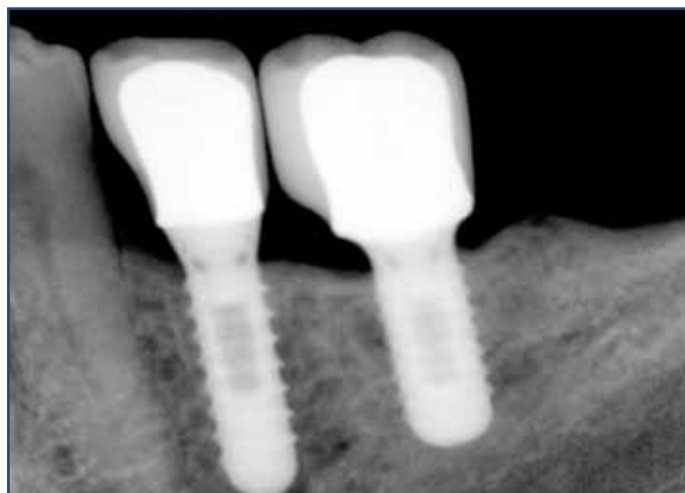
Blue Sky Bio® radiograph at 11 months post-op.
